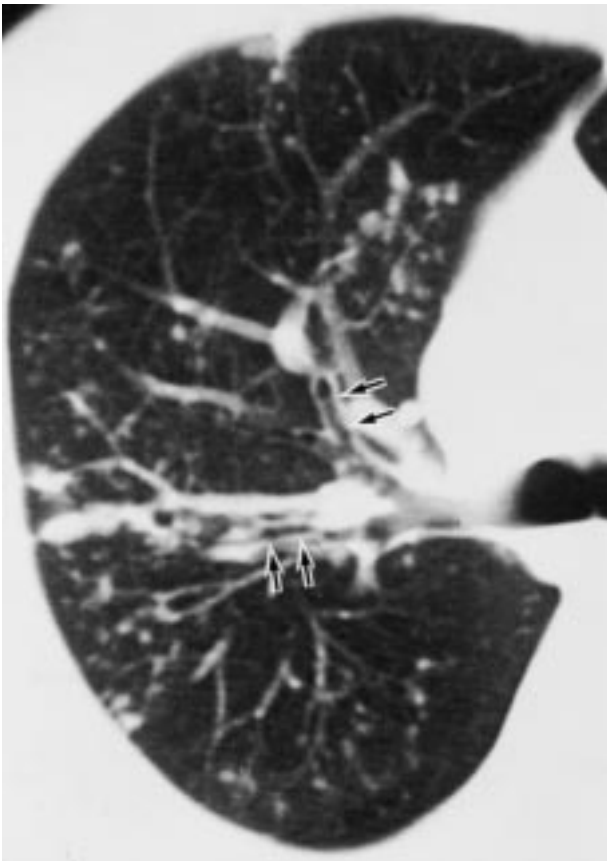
Preoperative chest computed tomography findings of bronchiectasis and bronchiolitis. Thickening of the bronchial walls from large to small airways were clearly demonstrated (arrows).
